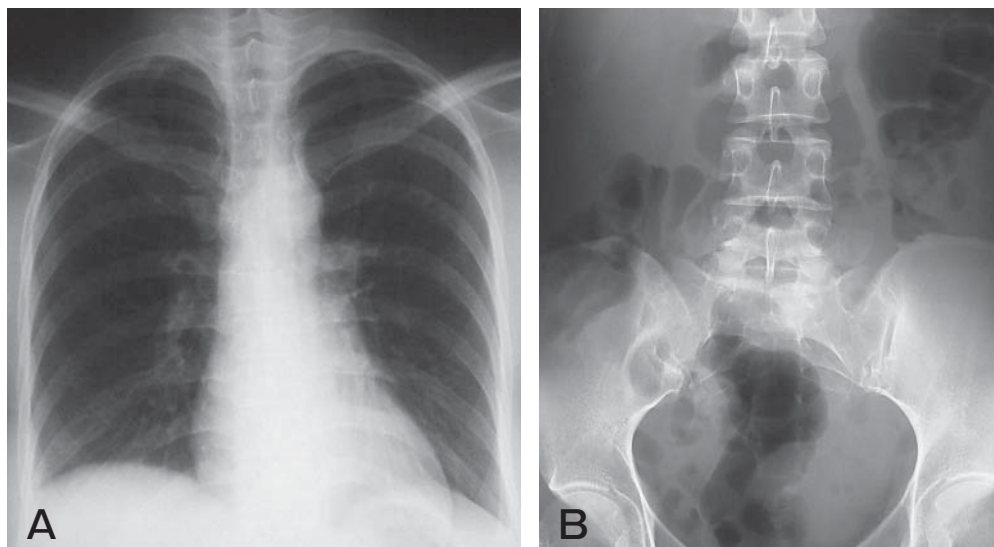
Initial radiographic chest and abdominal findings.
